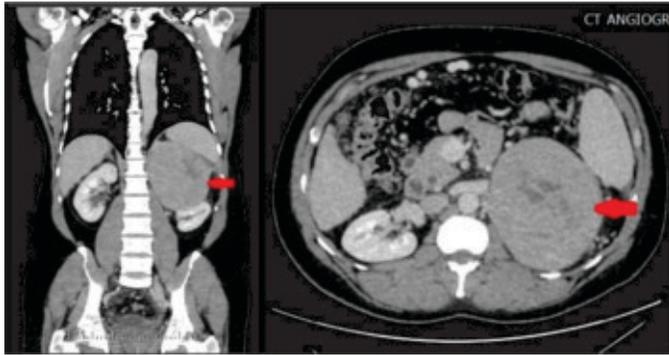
CT scan showing Left Suprarenal Mass in Hepatitis C-associated adrenal metastasis.
